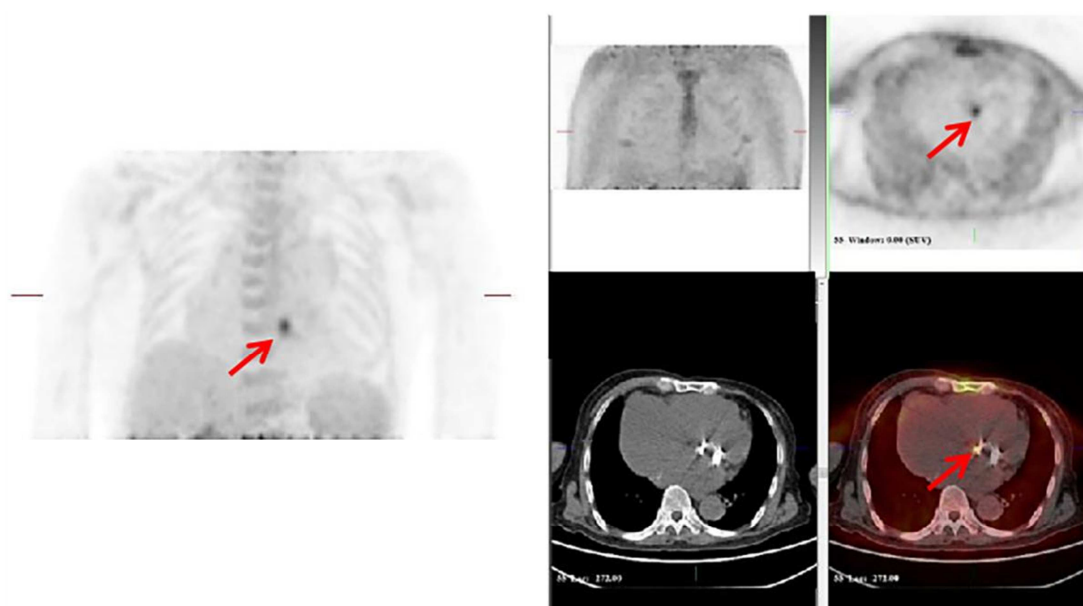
Different degrees of focal ^{18}F FDG uptake around the aortic prosthetic valves in another patient with culture-negative PVE caused by *Enterococcus faecalis*, which was detected by metagenomic next-generation sequence.
